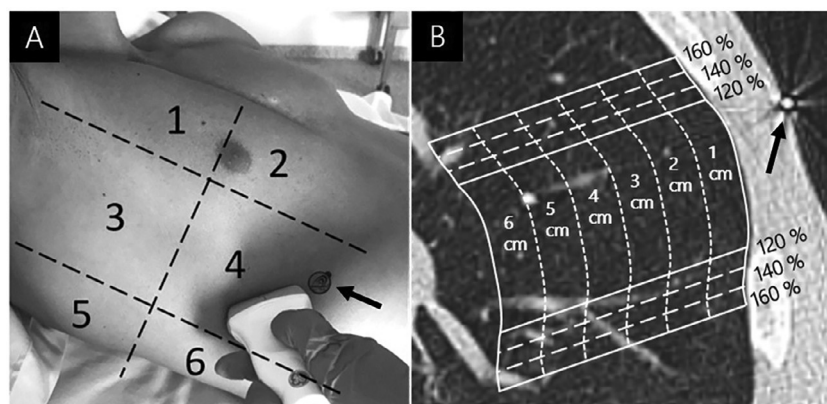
(a) Scanned lung regions and placement of radio-opaque markers (*arrow*) used to identify LUS regions on the CT image. (b) Radio-opaque marker including the corresponding lung region for different probe footprints and depths that were analyzed in CT. Multiple CT slices were analyzed per lung region. CT = computed tomography; LUS = lung ultrasound.
